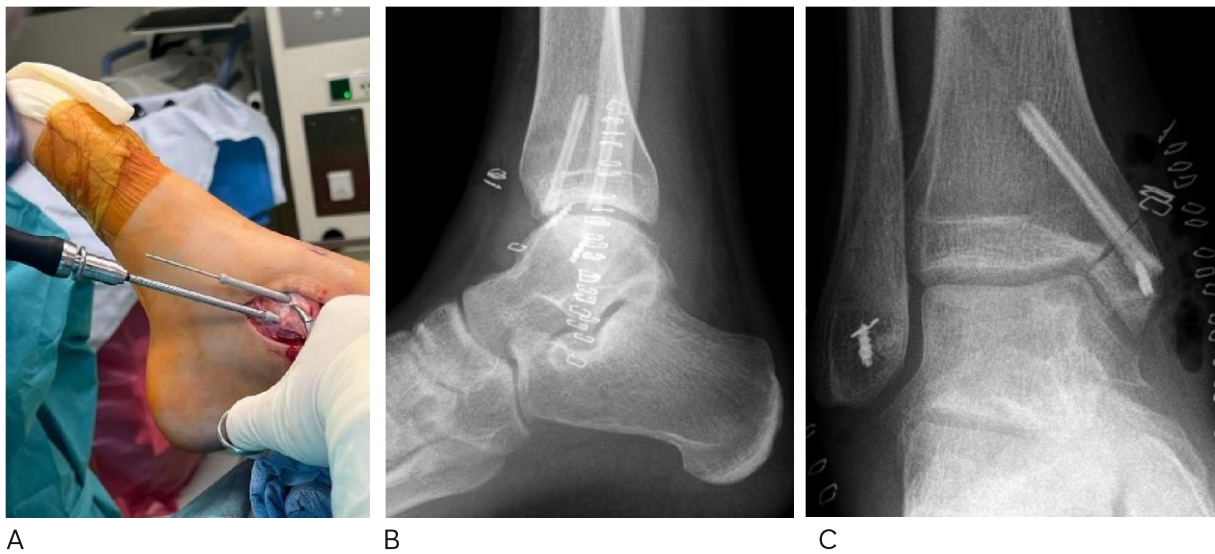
Refixation of malleolar osteotomy using cannulated bioabsorbable mm.CS 5.0 (A) and postoperative x-Ray Control after wound closure in saggital and frontal plane (B,C).
